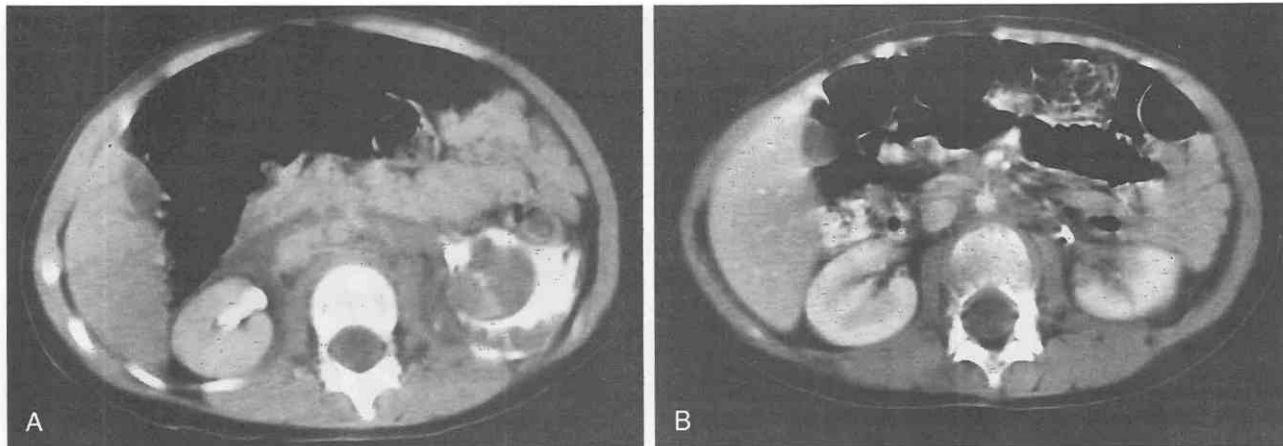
Left renal fracture with laceration of the collecting system and lower pole infarction in a 5-year-old girl who was run over by a bulldozer. *A*, Contrast-enhanced CT axial image through the lower poles of the kidneys several hours after the injury. The lower pole of the left kidney enhances very poorly, especially the lateral half. Perinephric extravasation of contrast material secondary to laceration of the collecting system has resulted in a large, opacified perinephric fluid collection surrounding the lower pole of the left kidney. The lower pole of the right kidney appears normal. *B*, Contrast-enhanced CT axial image through the lower poles of the kidneys 2 months later. The contour of the lower pole of the left kidney appears somewhat irregular. The medial portion of the lower pole still enhances poorly. The perinephric urinoma has resolved.
